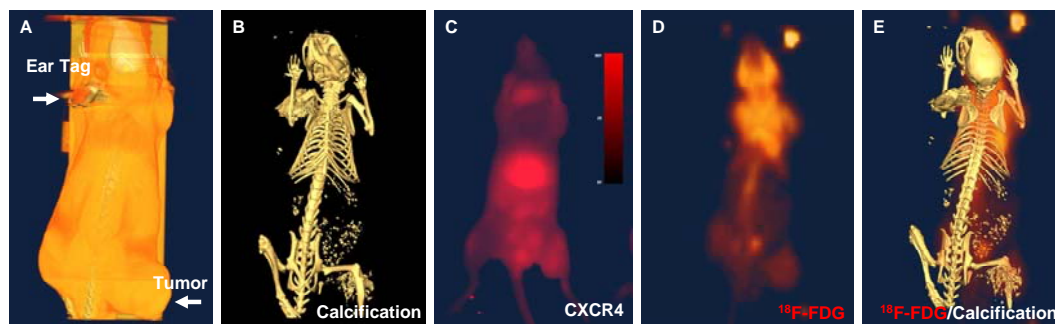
In vivo images of disease status in osteosarcoma xenografts. A. Whole-body CT image showing the location of the tumor. B. CT skeletal image demonstrating calcification in the tumor region. C. Near-infrared (NIR) image showing the distribution of CXCR4 agent in the thymus, liver, and osteosarcoma. D. FDG-PET image showing high level of glucose metabolism in the osteosarcoma region. E. Merged CT and PET images showing anatomical location of the tumor and whole-body CXCR4 signal distribution.
